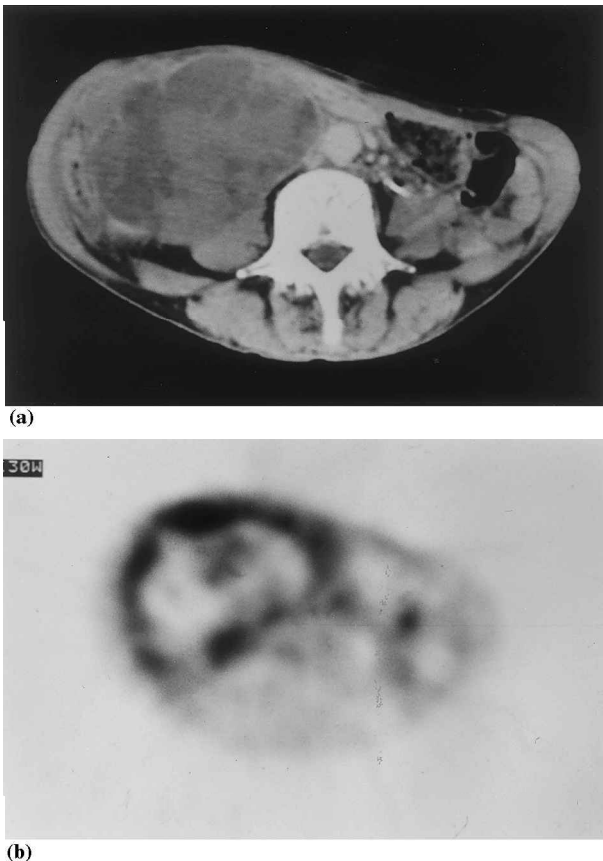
(a) Abdominal CT scan demonstrates a large retroperitoneal tumor 11 cm in diameter. (b) Positron emission tomography using ^{18}F -FDG PET shows a high uptake of FDG in the tumor, especially in the marginal region (SUV = 2.77).
